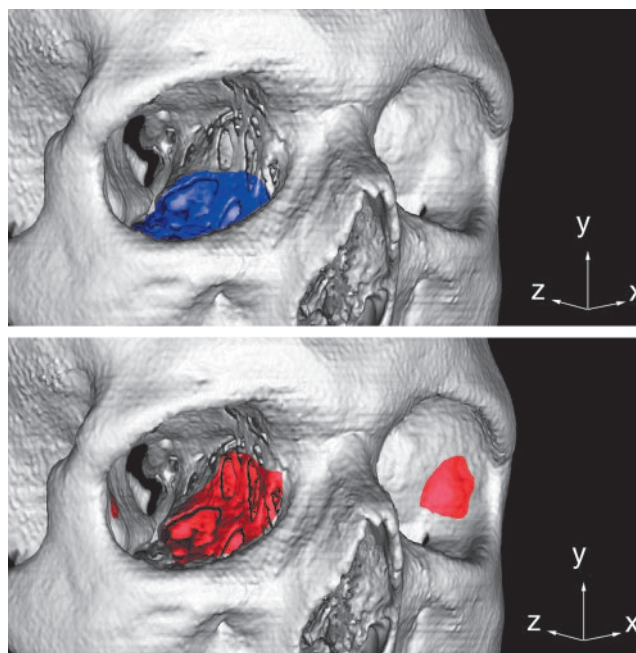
Osteotomies for (top) translid (two-wall) and (bottom) coronal (three-wall) decompression. Translid osteotomies are shown in blue and coronal osteotomies in red. The orbital walls and the anterior skull were volume rendered (<http://www.isi.uu.nl/people/michael>) from preoperative high-resolution computed tomography (CT) data. The medial orbit is very thin, and in some areas the bone is inaccurately absent. Arrows: orientations of the x-, y-, and z-axes.
